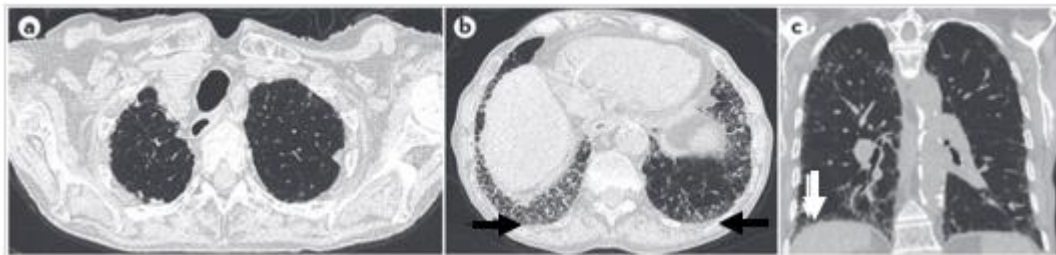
HRCT images from a patient with IPF. High-resolution CT (HRCT) images collected from a woman with progressive cough and dyspnea, showing her upper lung zones (panel a), lower lung zones (panel b), and the sagittal plane of the lungs (panel c). These images show lower lobe-predominant peripheral honeycomb change (panels b and c, arrows), a typical UIP pattern. (Modified from Martinez et al. 2017)
